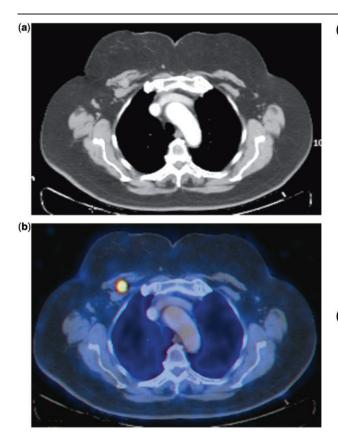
A 53-year-old woman with breast cancer. (a) CT reveals an enlarged rounded lymph node secondary to breast cancer spread between the pectoralis muscles. (b) The lymph node is visible as an area of increased FDG uptake on PET/CT.
